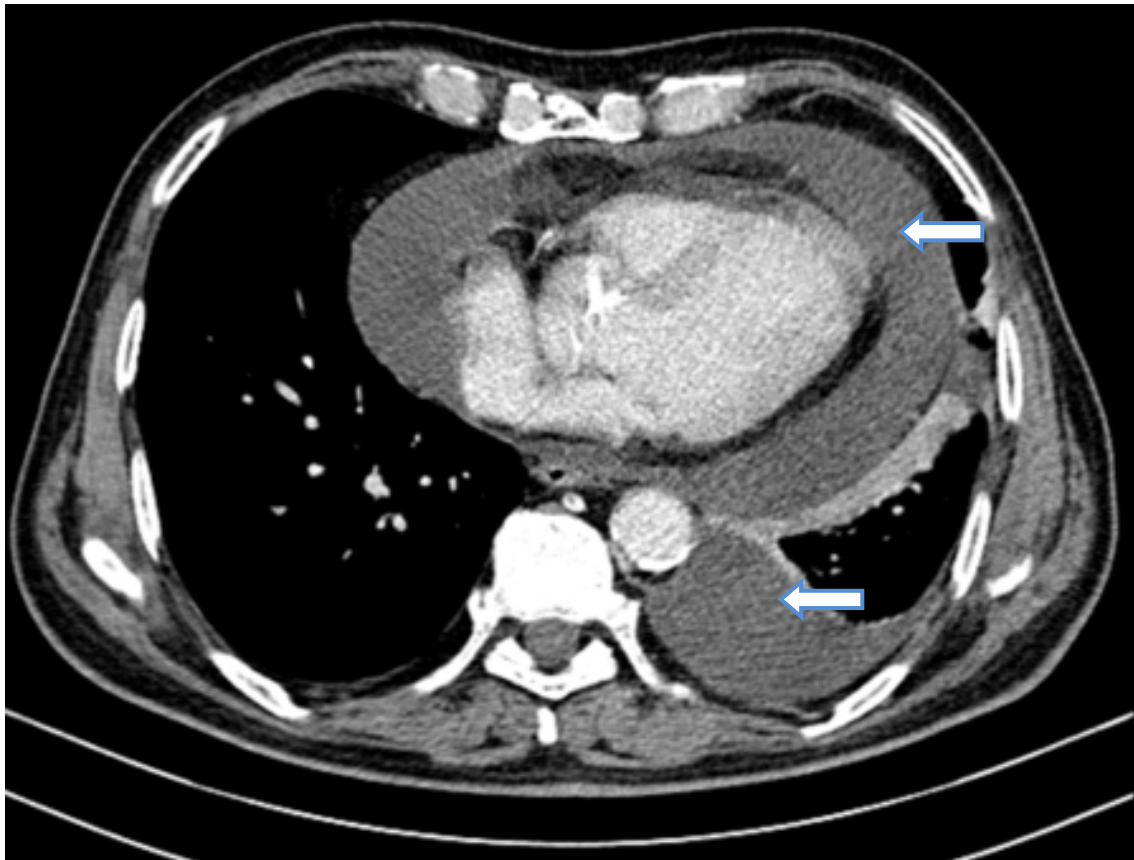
CT exam Showing Pleurisy and Pericardial Effusion After the Initiation of Treatment with Nivolumab.
